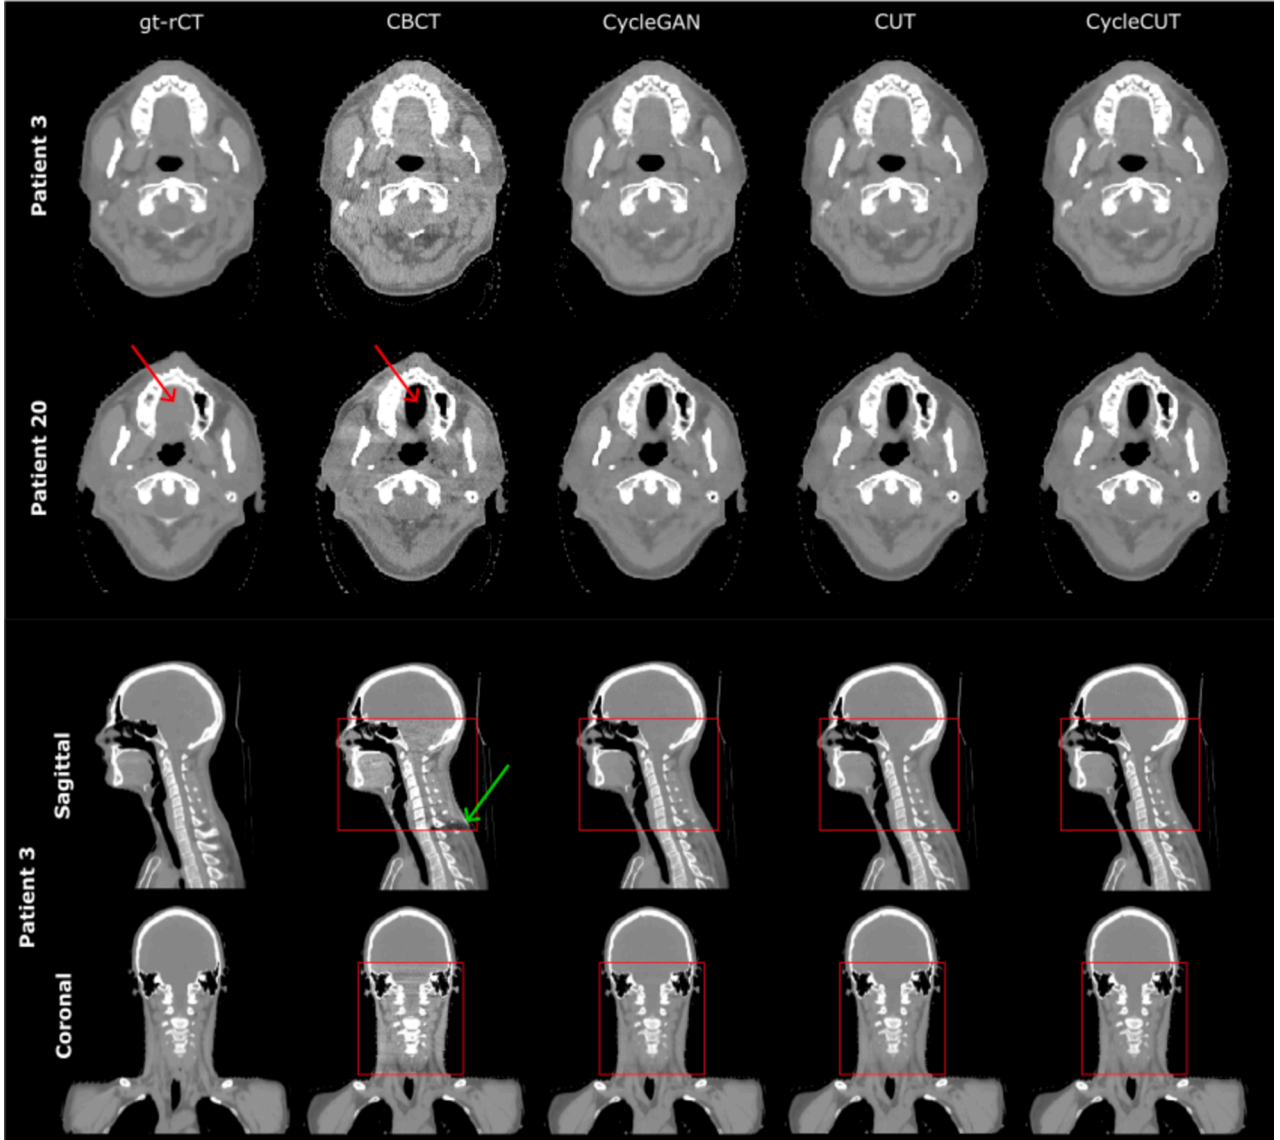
(Top) Axial slices of gt-rCT, CBCT, and sCTs for two patients (Patient 3 and 20, see Section S2 in supplementary material), representing a good (Patient 3) and less optimal (Patient 20) anatomical correspondence between the gt-rCT and CBCT (red arrow on gt-rCT and CBCT for Patient 20). (Bottom) Sagittal and coronal views of Patient 3. The green arrow on the sagittal view of the CBCT shows an artifact that has been corrected on all sCTs. The CBCT field-of-view is indicated by a red box. All images are displayed in the same window level/width setting (0 HU/800 HU).
